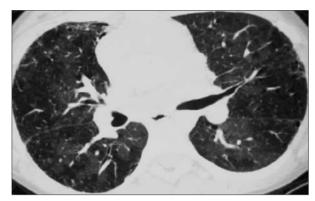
High-resolution computed tomography (expiratory views) demonstrating air-trapping.
